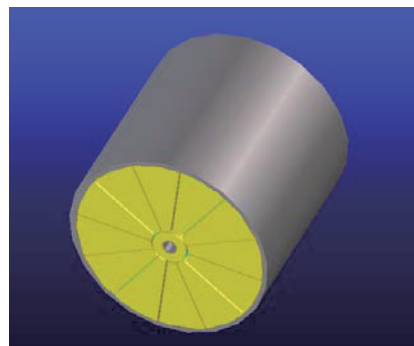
Ring-array-type ultrasonic probe.
